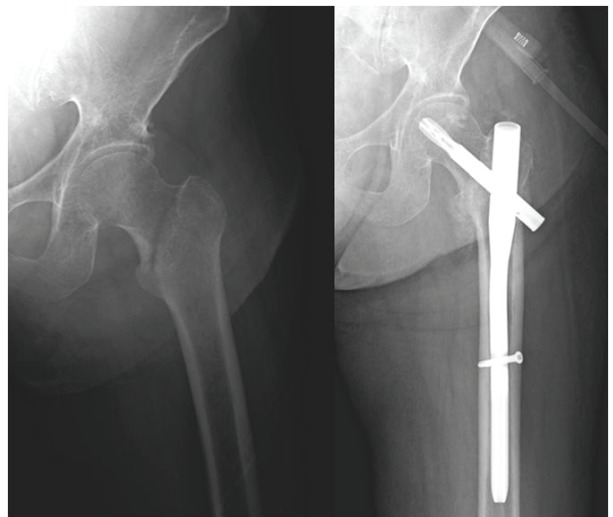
Pre- and post-operative AP X-ray of a 78-year-old patient with stable intertrochanteric femur fracture that was treated with PFN
